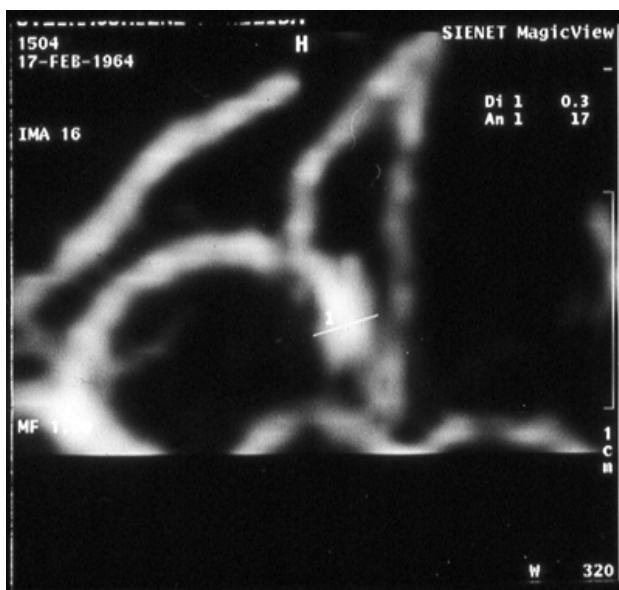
Brain CT angiography 3D reconstruction with MIP (maximum intensity pixels). Aneurysm of the anterior communicating artery (grey arrow).
